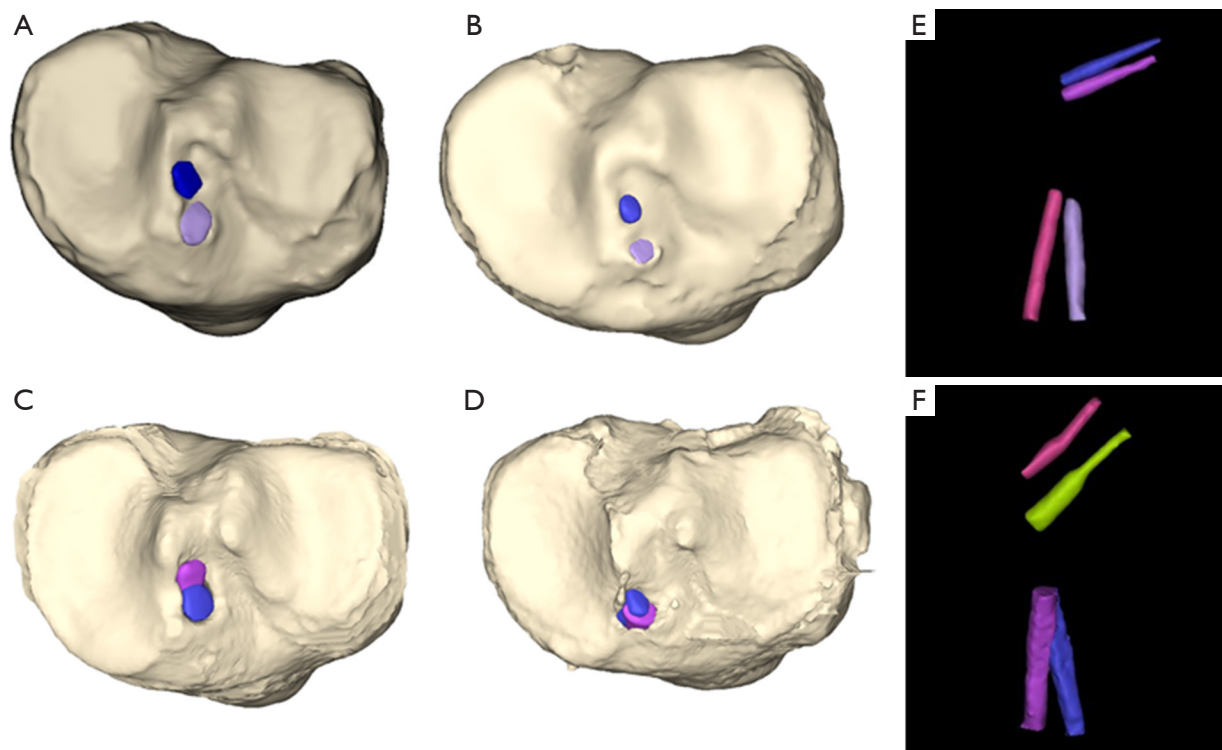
Tibial tunnel coalition after DB ACL reconstruction. The three-dimensional computed tomography created by Mimics software version 24.0 (Materialise, Leuven, Belgium) shows the bony tunnel on the tibial side after DB ACL reconstruction. A and B have no tibial tunnel coalition, while C and D have tunnel coalition. E and F are extracting the bony tunnel of the tibia and femur. (F) The tunnel coalition occurs near the articular surface of the tibia. If the tunnel coalition occurs, it is not a true DB and stability may be affected. DB, double-bundle; ACL, anterior cruciate ligament.
